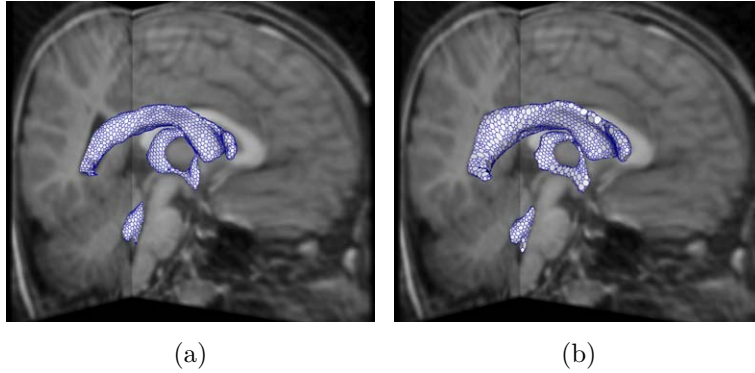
Examples of deformation steps with the ventricle simplex mesh: (a) After geometric adjustment by affine transformations (sec. 2.3.3). (b) After deformation to match the ventricle borders in the MRI image.
